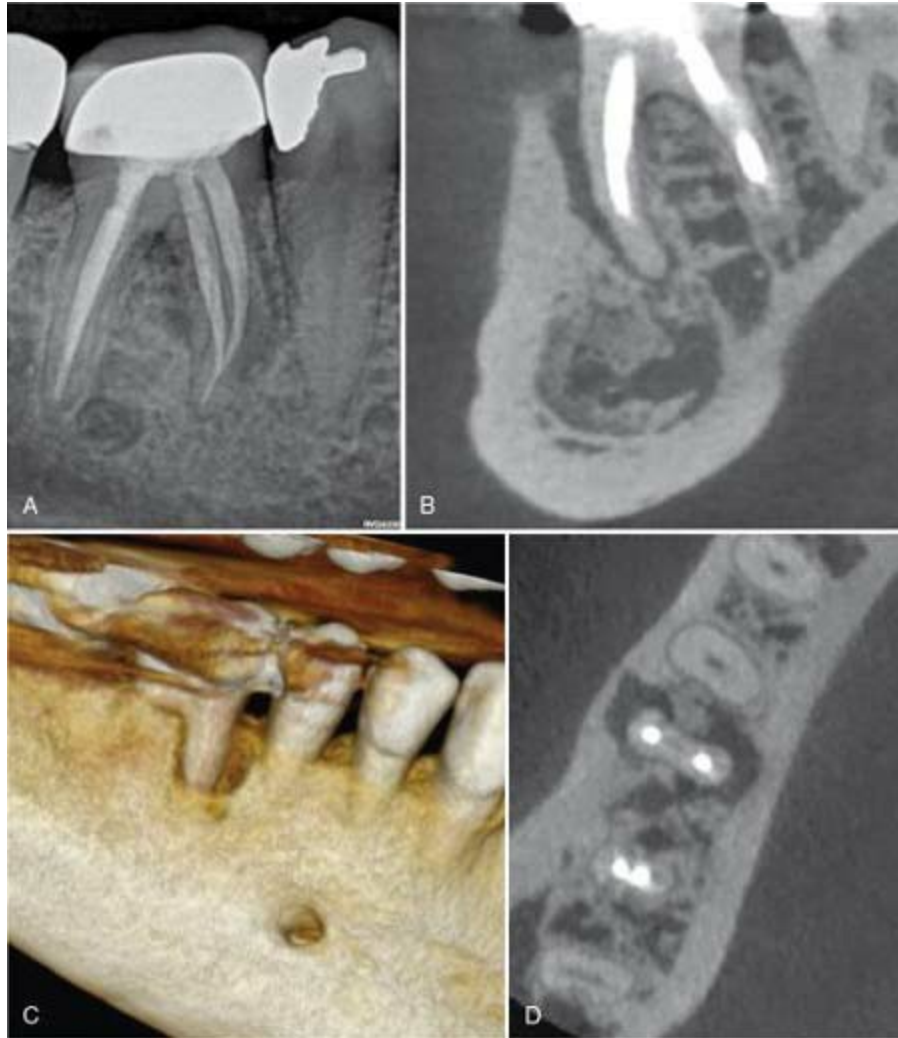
A, Periapical radiograph of mandibular right first molar revealing suspected periradicular bone loss. B, Cone-beam computed tomography (CBCT) sagittal view of same tooth revealing bone loss from crestal bone to apex. C, CBCT anatomic view revealing mesial osseous defect. D, CBCT axial view revealing buccal and lingual bone loss midroot.
